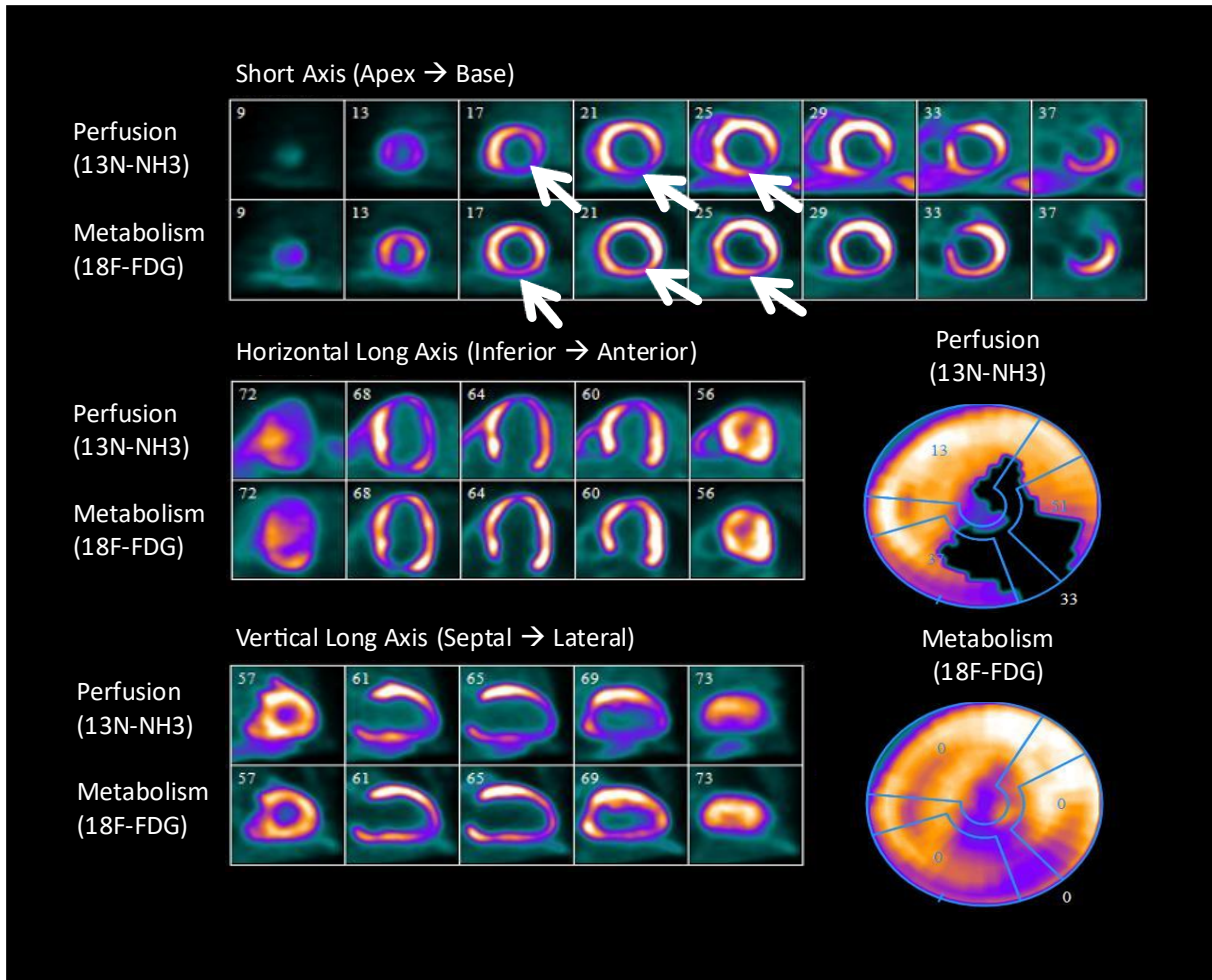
Example of assessment of myocardial viability with PET-CT with fixed myocardial inferolateral perfusion defect but with 18F-FDG uptake (viable). Top rows: 13N-ammonia (13N-NH3) is used as a tracer of myocardial blood flow at rest in short axis images starting at the apex and moving toward the base of the heart (upper image), horizontal long axis (middle image) and vertical long axis (lower image). Myocardial perfusion is markedly decreased in the apical, inferior and inferolateral regions (white arrows). Bottom rows: 18F-fluorodeoxyglucose (18F-FDG) is used as a tracer of myocardial glucose metabolism. 18F-FDG uptake is enhanced relative to blood flow, demonstrating a pattern of perfusion-metabolism mismatch (white arrows) in the abnormally perfused myocardial regions, indicative of viable or hibernating myocardium. Polar map of viability study: the upper polar map plot displays the extent of the rest perfusion defect (black area). The lower polar map plot shows 18F-FDG uptake in the rest perfusion defect area indicating metabolic viability. Image source: ICNAS (Instituto das Ciências Nucleares Aplicadas à Saúde). Modified from reference 12.
